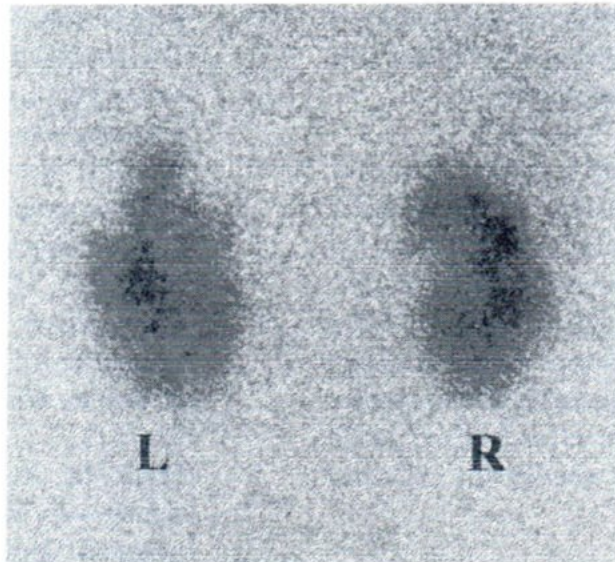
Follow-up scintigraphy 6 months after acute infection in a 9 years old girl showing multifocal scars in upper pole of left kidney (L). Right kidney (R) is normal. During acute infection uptake defect was observed in each pole of left kidney.
